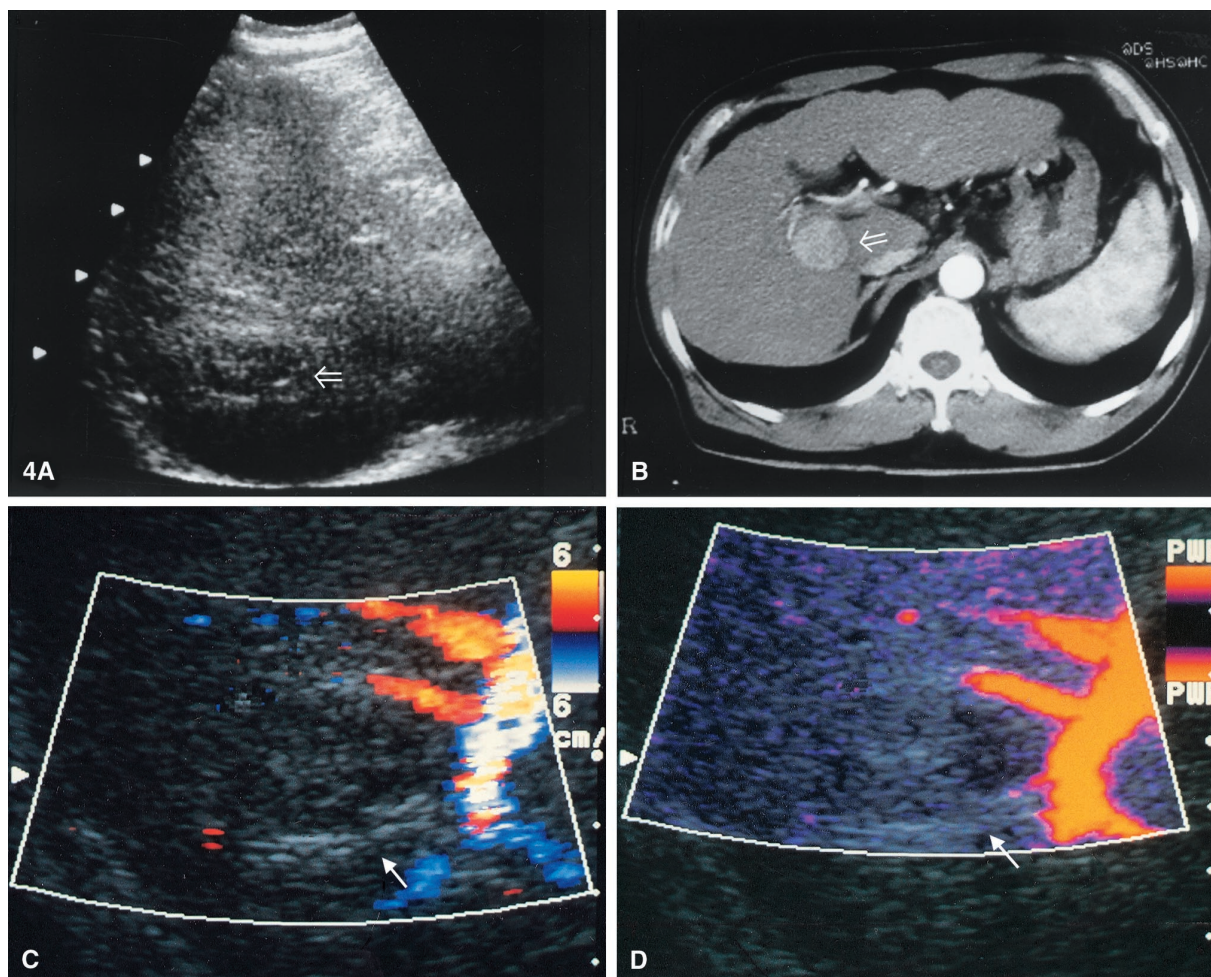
Hepatocellular carcinoma in the right hepatic lobe, 2.5 cm at its greatest diameter and 10 cm deep. A Gray-scale ultrasonography shows a hypoechoic nodule (arrow). B Dynamic computed tomography shows nodular enhancement (arrow) in the arterial phase. Color Doppler sonography (C) and power Doppler sonography (D) show no color signal within the lesion (arrow).
